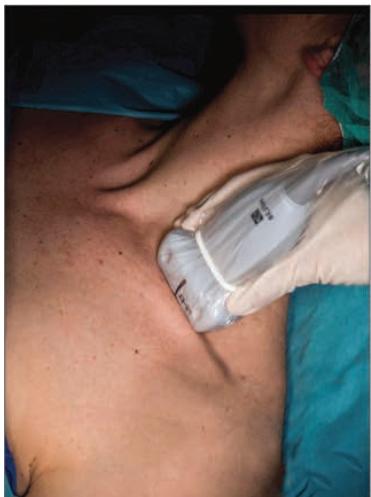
Transducer position and ideal ultrasound image for a suprascapular nerve block at the supraclavicular fossa. SA, subclavian artery; LT, lower trunk; UTa and UTp, upper trunk anterior and posterior divisions; MTa and MTp, middle trunk anterior and posterior divisions; OHM, omohyoid muscle; MSM, middle scalene muscle.
